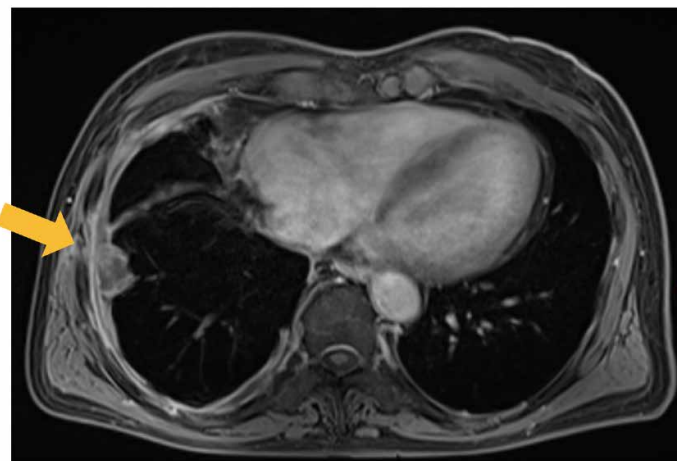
Thoracic MRI showing PM chest wall infiltration on the right seventh intercostal space laterally
